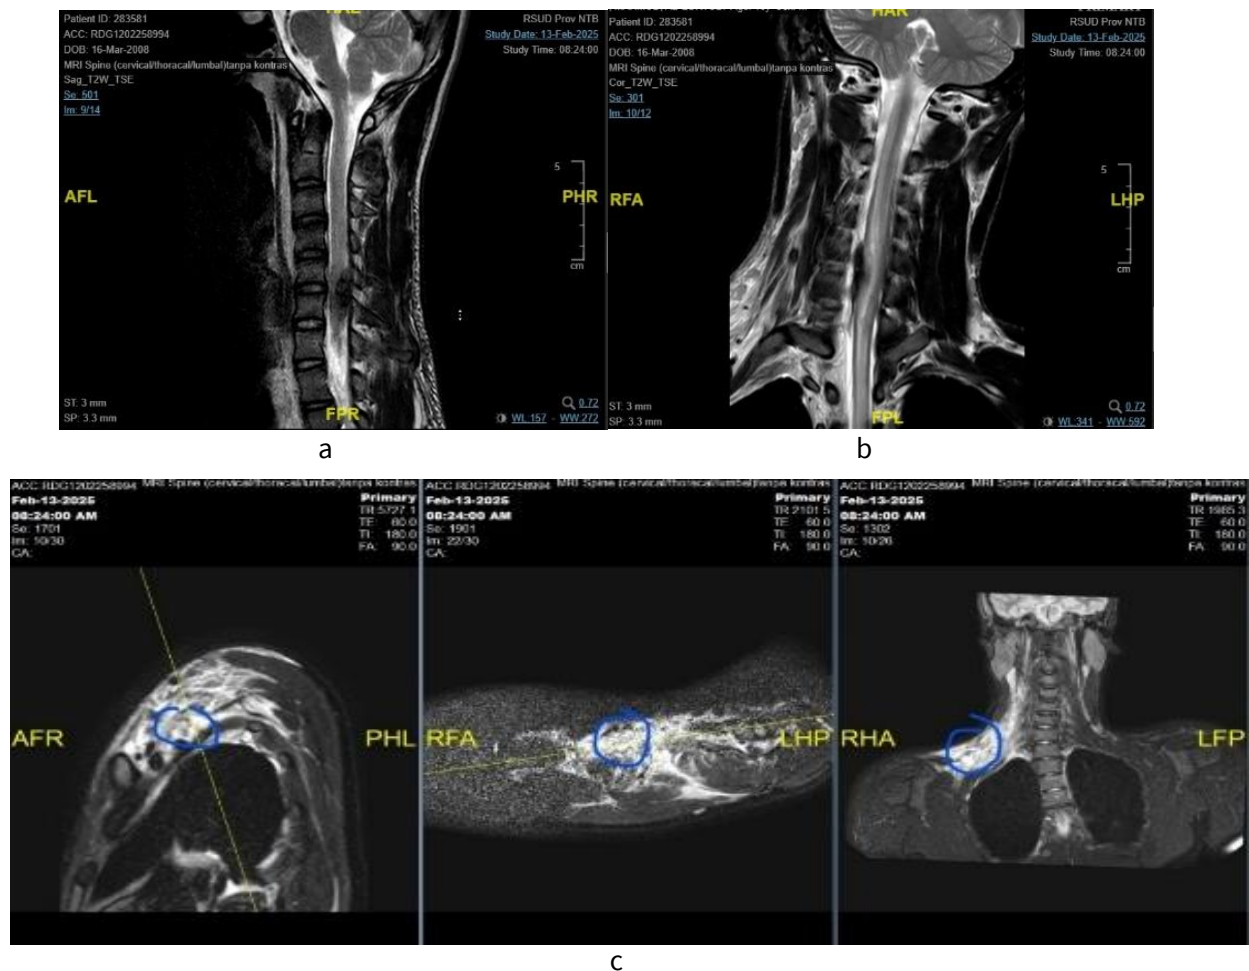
Magnetic Resonance Imaging (MRI) examination on 12th February 2025.
